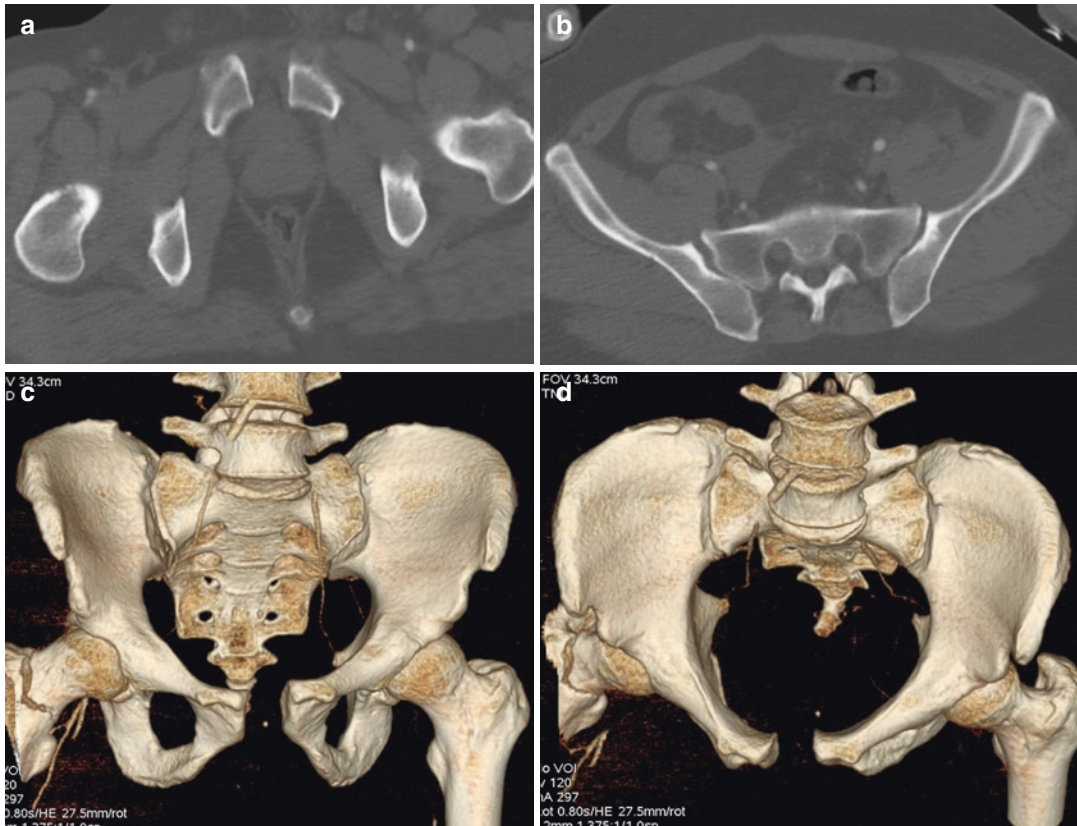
(a–d) Anterior-posterior compression (APC) fracture, type II. (a–c) CT axial view (a) and CT 3D (VR) reconstruction AP view (c) show diastasis of the pubic symphysis >2.5 cm; (b, d) axial view (b) and CT 3D (VR)
